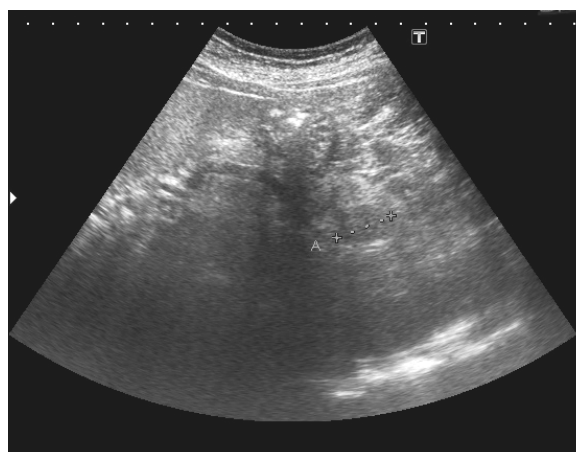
Transverse ultrasound image showing a 1.8 cm × 2.3 cm, homogeneous, well-defined, round hypoechoic mass in the pancreatic tail.
